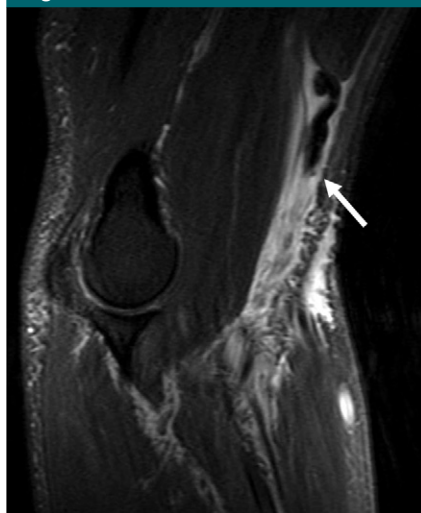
Sagittal T2-weighted FS MR image in a 48-year-old man with an acute injury lifting weights depicts avulsion of the distal biceps tendon with the tendon end retracted proximally (arrow).
